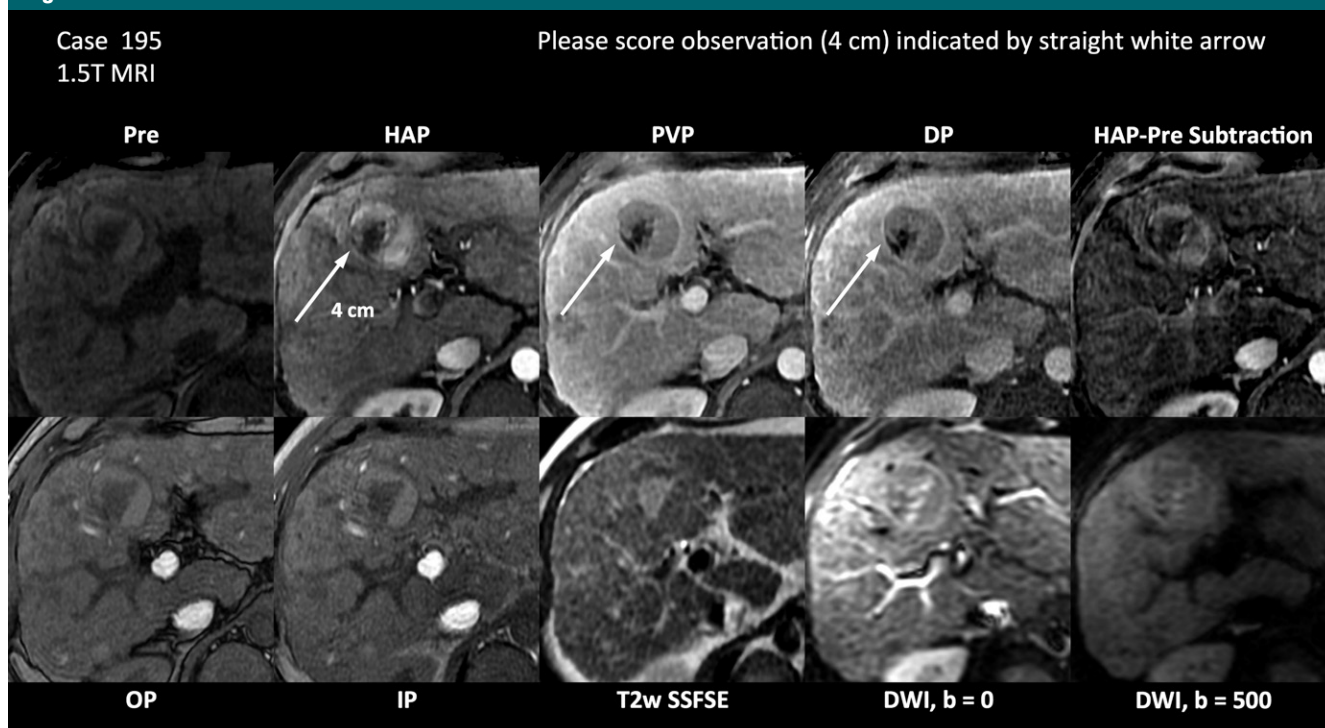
MR image set shows an LR-5 observation (arrows) with high agreement. The image set is exactly as it was presented to reviewers. All (100%) reviewers chose LR-5 as the category. *DP* = delayed phase, *DWI* = diffusion-weighted imaging, *HAP* = hepatic arterial phase, *IP* = in phase, *OP* = opposed phase, *Pre* = precontrast, *PVP* = portal venous phase, *SSFSE* = single-shot fast spin-echo, *T2W* = T2-weighted.
